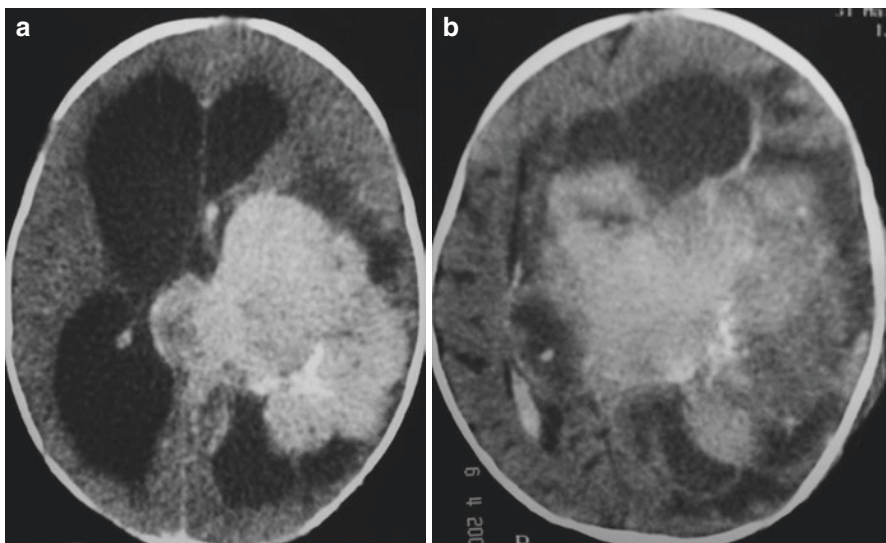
CT Scan of a 4-month-old male with macrocrania and respiratory distress. A left ventricular tumor (a) that increased in volume after hemorrhage 5 days after admission (b). After a needle biopsy, the diagnostic was PNET
